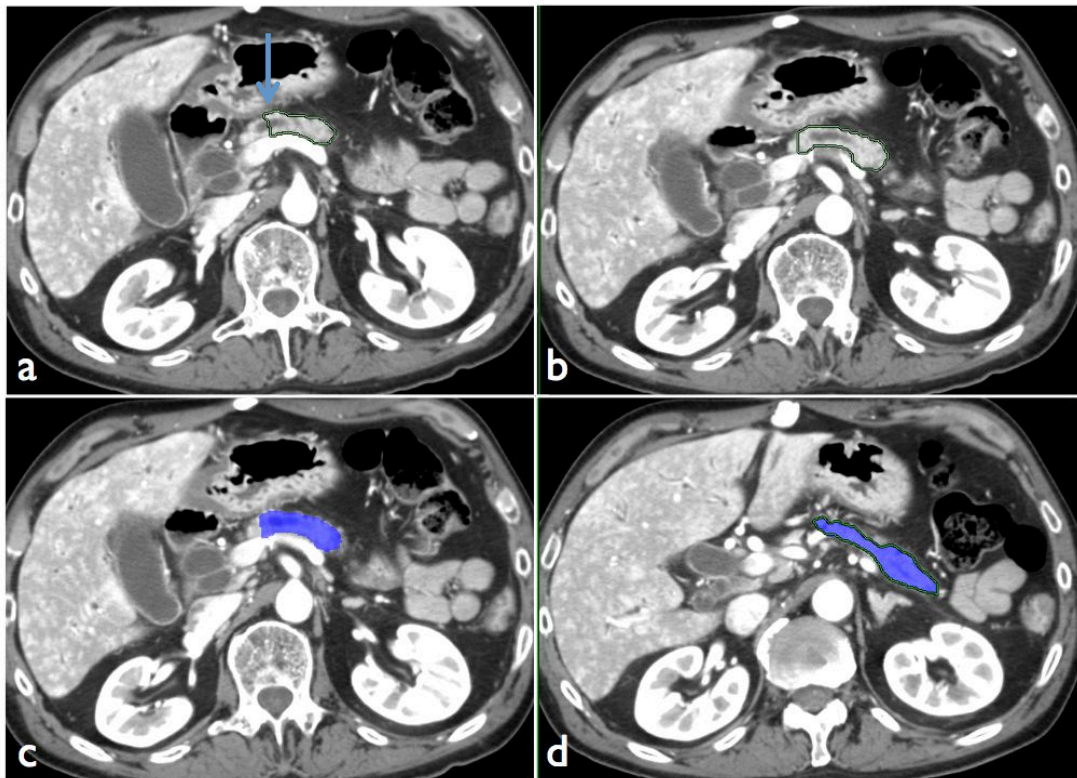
This is a CT examination performed according to our institution's standard protocol (PS) in a patient with ductal adenocarcinoma in the head of the pancreas. The four images show how the pancreatic remnant volume was estimated. With a semiautomatic segmentation technique, the pancreas can be delineated (green line), first at the level of the alleged resection line (blue arrow) and then several sections toward the tail (image b). The intermediate sections are automatically bordered (blue areas).
